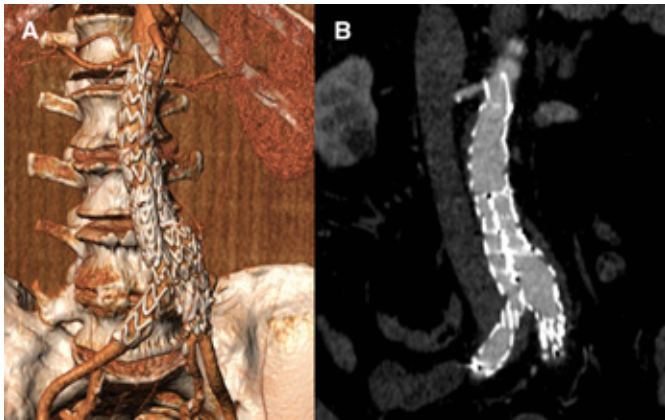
The CTA at 30-day follow up depicting a A) 3D reconstruction and B) coronal plane and demonstrating no sign of endoleak and an adequate graft position and patency
